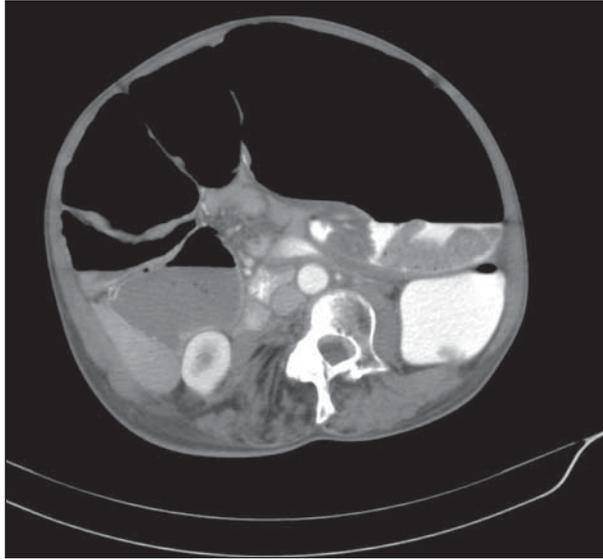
Computed tomography of abdomen with oral contrast showing massive dilatation of the colon owing to sigmoid volvulus.
